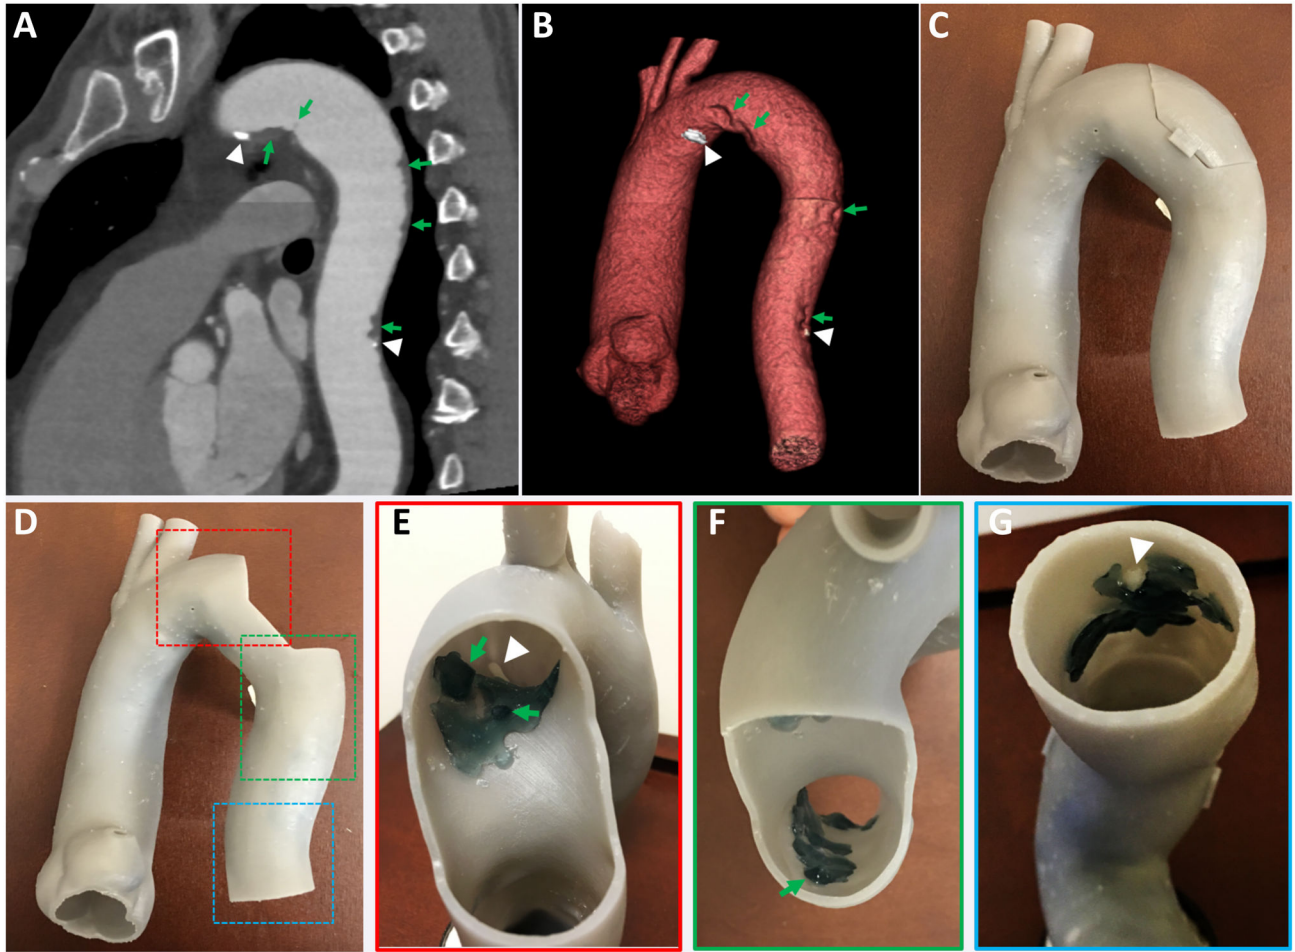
Model of aortic wall with mobile mural thrombi generated from CTA
